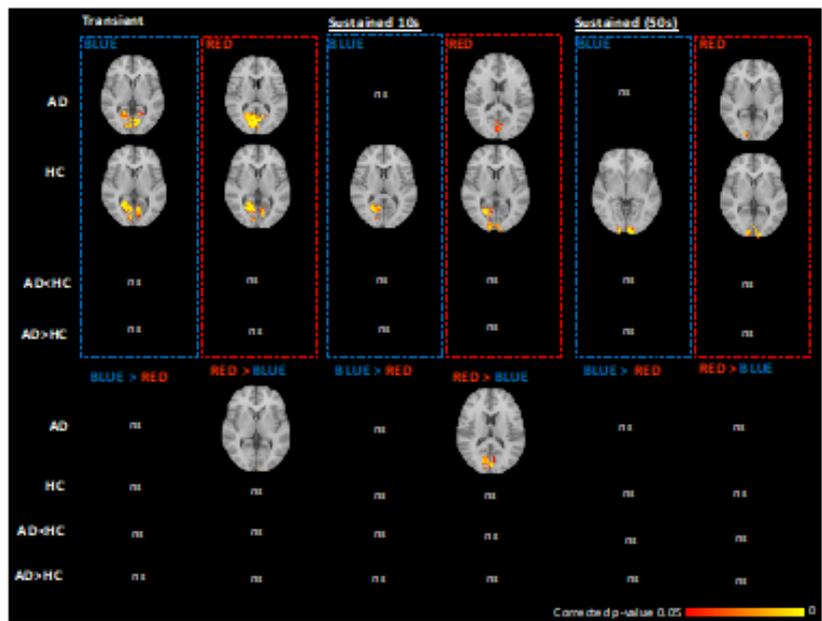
Brain functional MRI studies with light stimuli in AD and control
